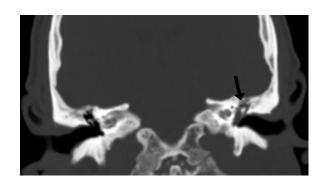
Noncontrast coronal head CT, in a bone window, demonstrates a left middle ear effusion (black arrows). ENT performed a left myringotomy which returned mucopurulent fluid; cultures were negative.
